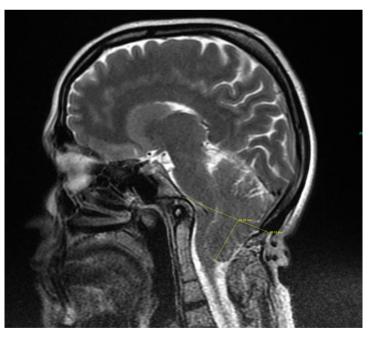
Sagital magnetic resonance image of Chiari type I malformation [28.2 mm tonsillar herniation from the cerebellum].
